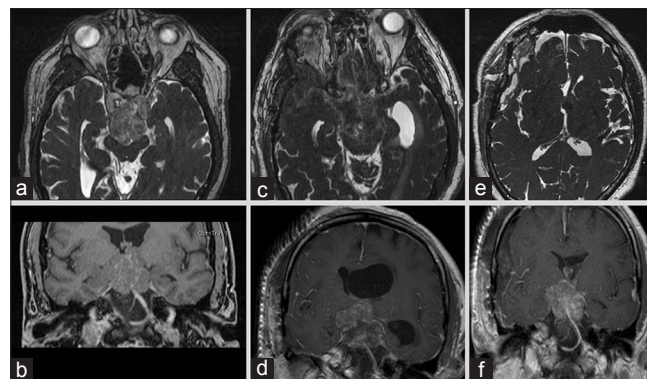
Constructive interference in steady state axial and T1 - post-contrast coronal magnetic resonance imaging sequences showing pre-craniotomy (a, b), post-craniotomy (c, d), and following debulking of the third ventricular portion of the tumor and septostomy (e, f).
